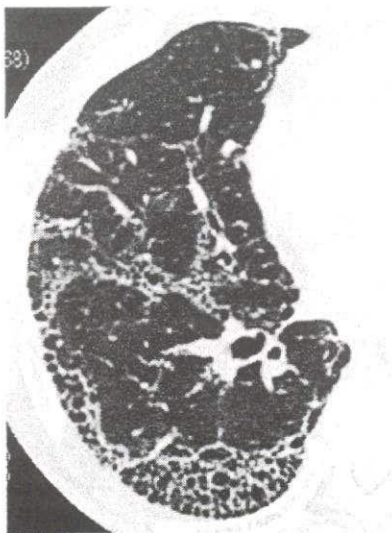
Definite usual interstitial pneumonia pattern in a 57-year-old man. Transverse computed tomography (CT) images obtained with 2-mm section thickness. Thin-section CT image through the right lower lobe demonstrates honeycombing in a predominantly peripheral distribution.
